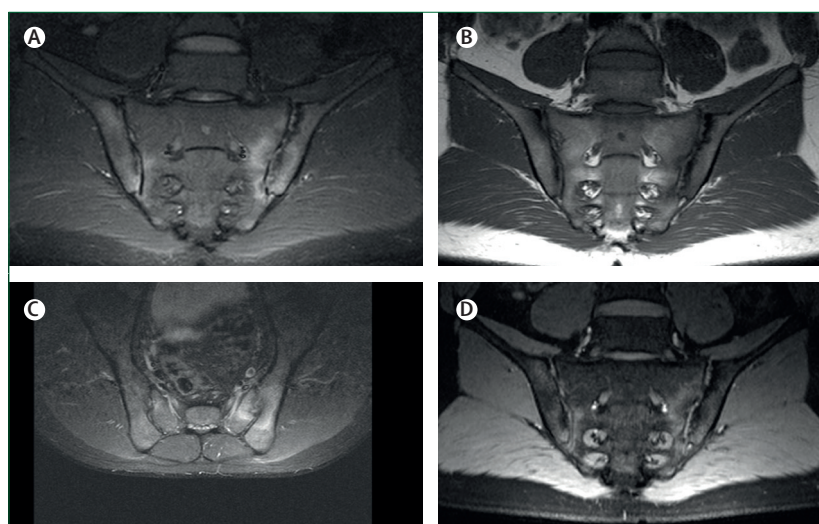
Examples of images according to the ASAS-SPARTAN proposed image acquisition protocol (A) Semi-coronal orientation, STIR sequence. (B) Semi-coronal orientation, T1-weighted sequence. (C) Semi-axial orientation, STIR sequence. (D) Semi-coronal orientation, VIBE sequence.⁶⁰ ASAS=Assessment in SpondyloArthritis international Society. STIR=short tau inversion recovery. VIBE=volumetric interpolated breath-hold examination.
